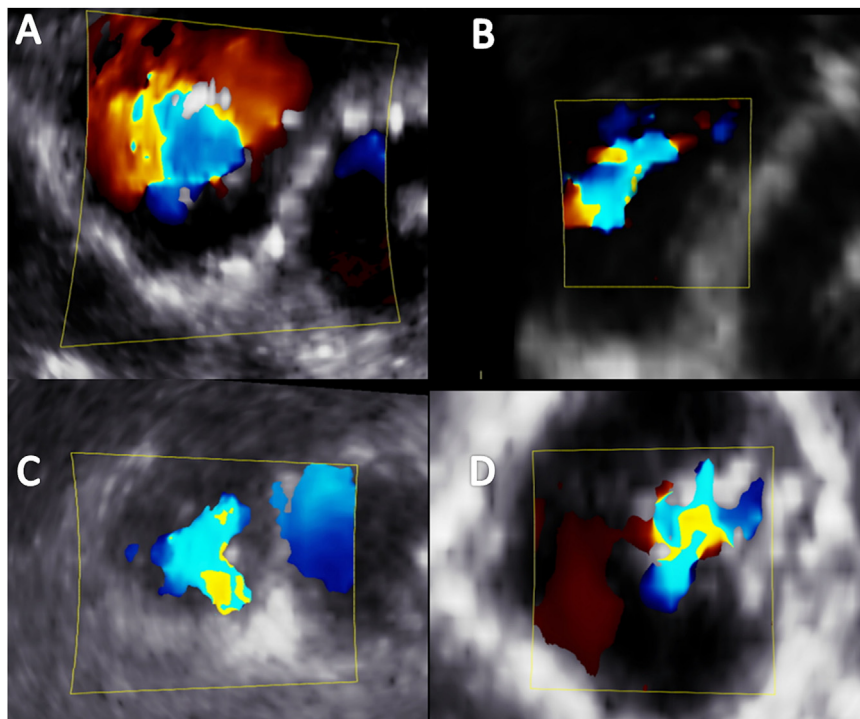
Variability of the shape of the VC among patients with STR. Transthoracic 3D color Doppler echocardiography with transverse cut planes obtained at the level of the VC of the regurgitant jet. The panels show distinct morphologies of the VC: circular (A), ellipsoid (B), crescent (C), and stellate (D).
